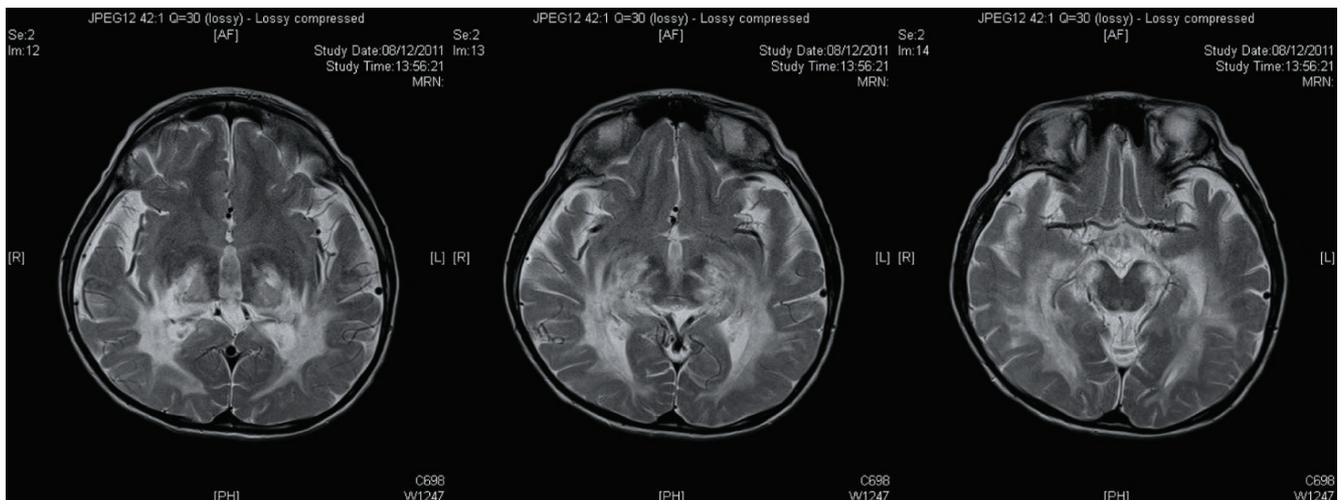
Cranial MRI at age of 6 years old and 1 month showing markedly increased extensive leukodystrophic changes.
